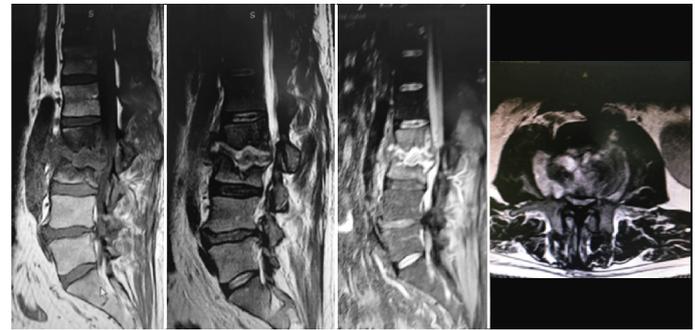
Case 35. MRI sagittal sections T1, T2 and T2 with contrast and Axial T2. Defined as L2-L3, A, C2, O2, +. (Region L2-L3, Anterior Location, the PSEA compresses the content, Association with disc and bone infection, Lateral Perivertebral/Psoas).
